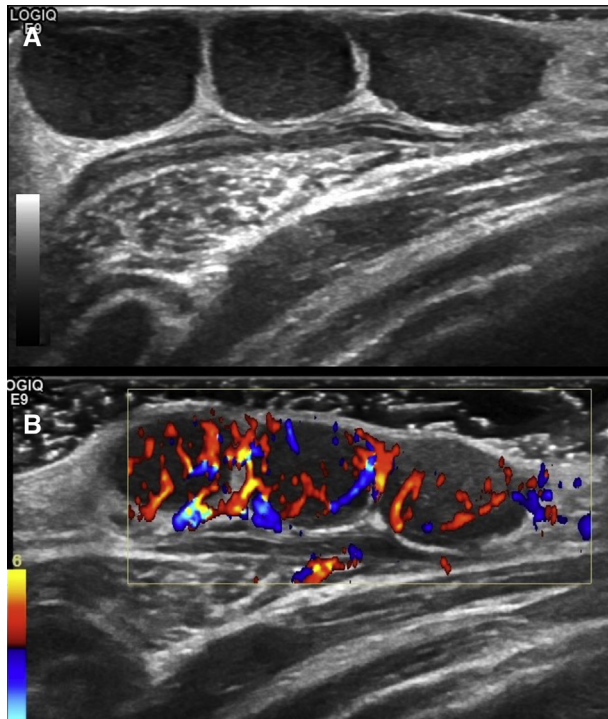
A, US examination shows a well-defined polylobulated hypoechoic soft tissue mass with polycyclic margins ($3 \times 2, 5 \times 1$ cm in diameter) within the subcutaneous tissue. The lesion is not well compressible. B, On color-Doppler evaluation, there was evidence of intralesional arterial and venous flow signals.
